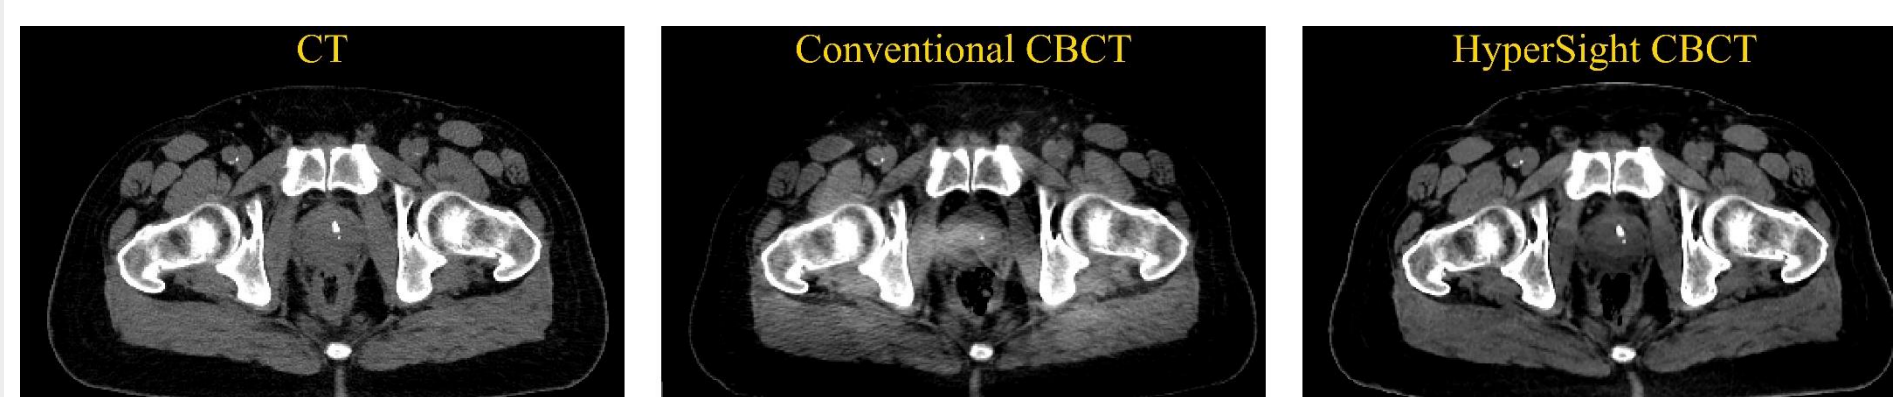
Representative pelvic axial slice comparison across modalities. Planning CT (left), conventional CBCT (middle), and HyperSight CBCT (right)
